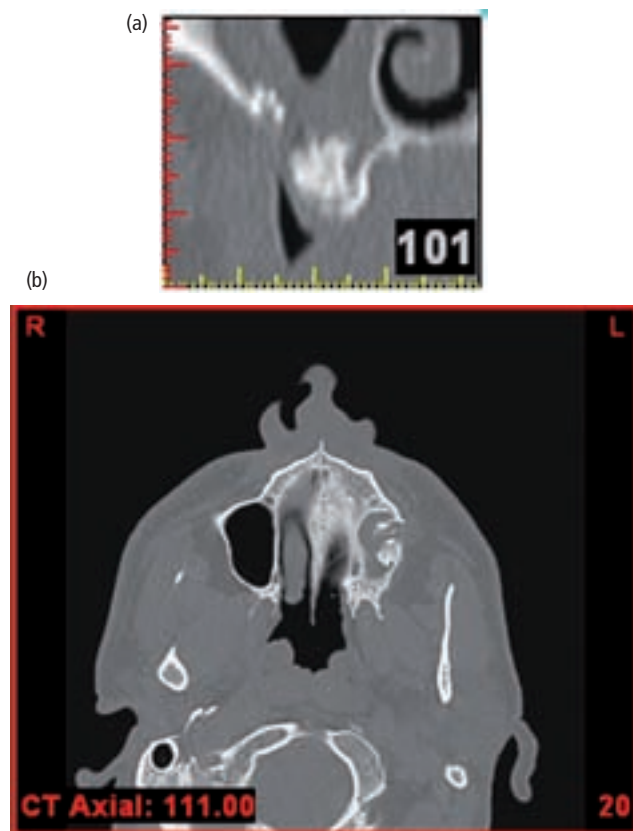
(a) Cross-sectional CT-scan view showing defect in lateral wall. (b) Axial CT-scan view showing defect in lateral wall (left).
